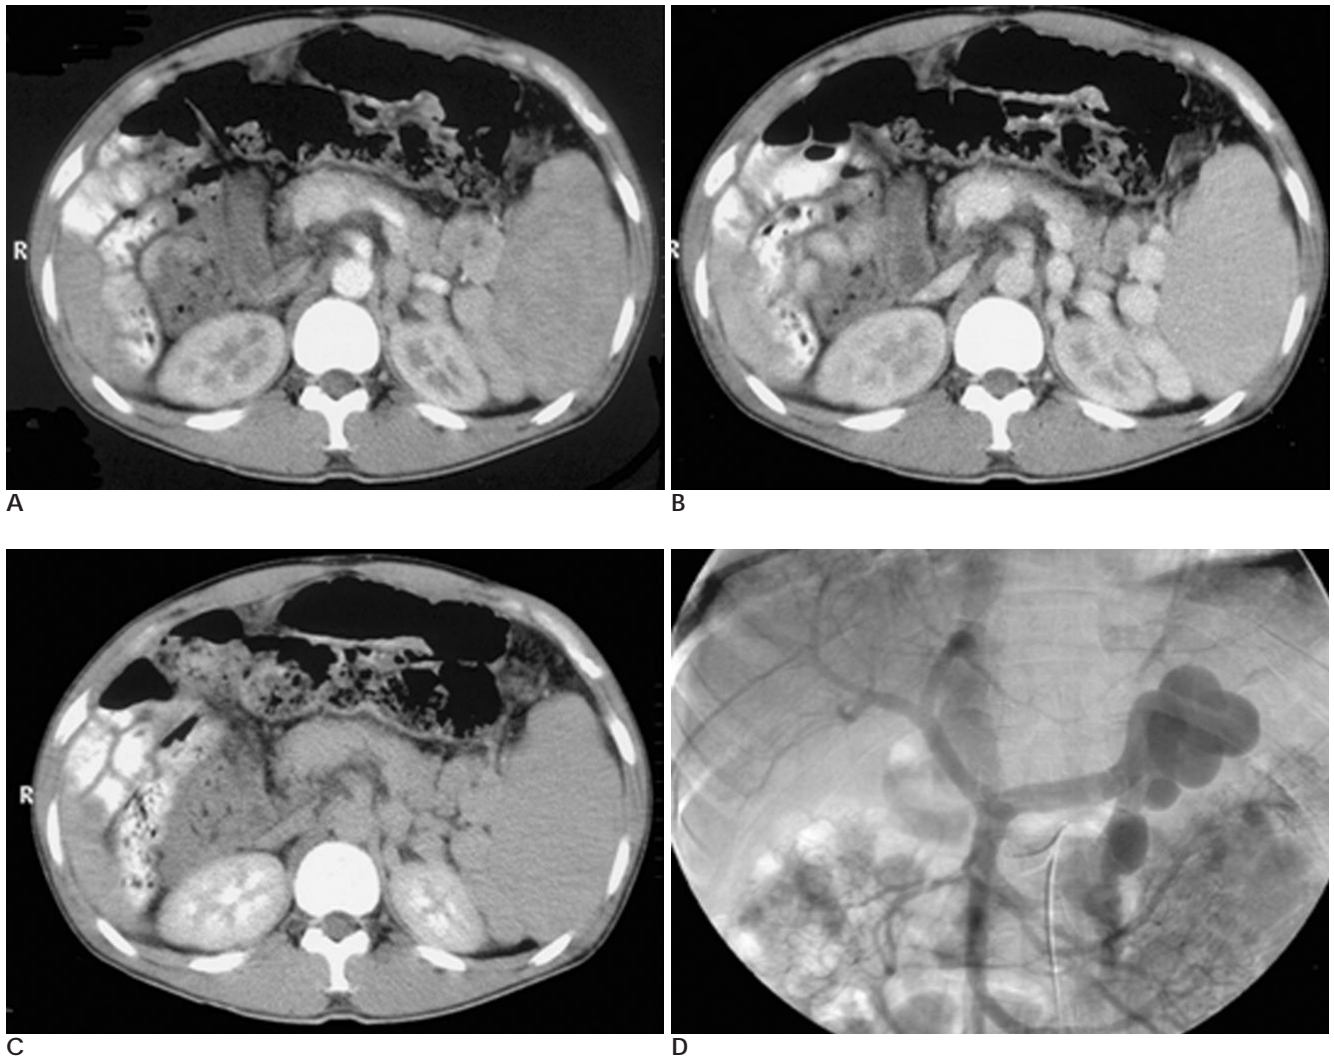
A three-phase CT scan (A-arterial phase, B-portal phase, C-delayed phase) and arterial-portography (D) performed in a patient with a renal shunt. Much of the portal venous inflow is diverted through the renal shunt, showing early opacification of the inferior vena cava. Prominent hypoperfusion of the renal cortex (108 HU in A, 112 HU in B, 107 HU in C) is noted in the images of the three phases studied. This patient has no ascites.
